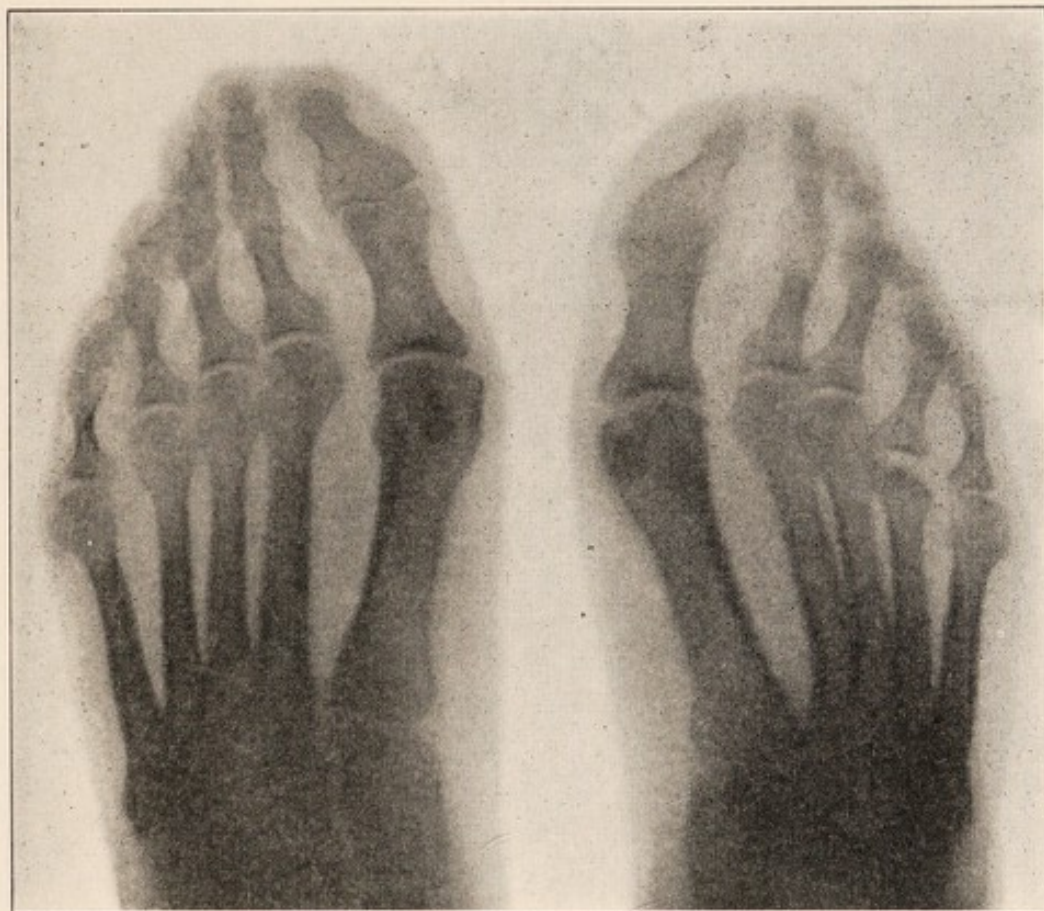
X-ray of moderate hallux valgus.
